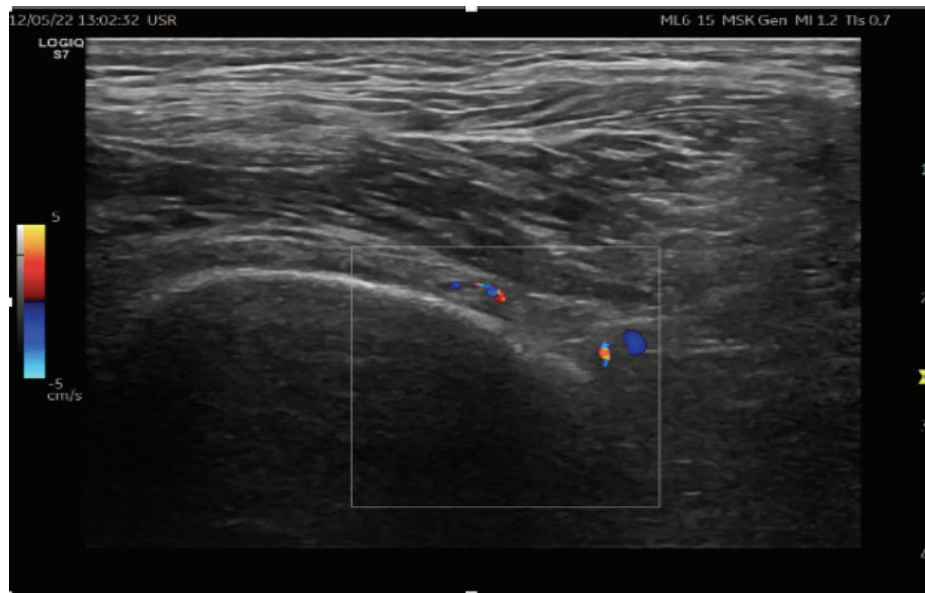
Ultrasound-guided identification of GNB target sites (SGN and the accompanying genicular artery).
